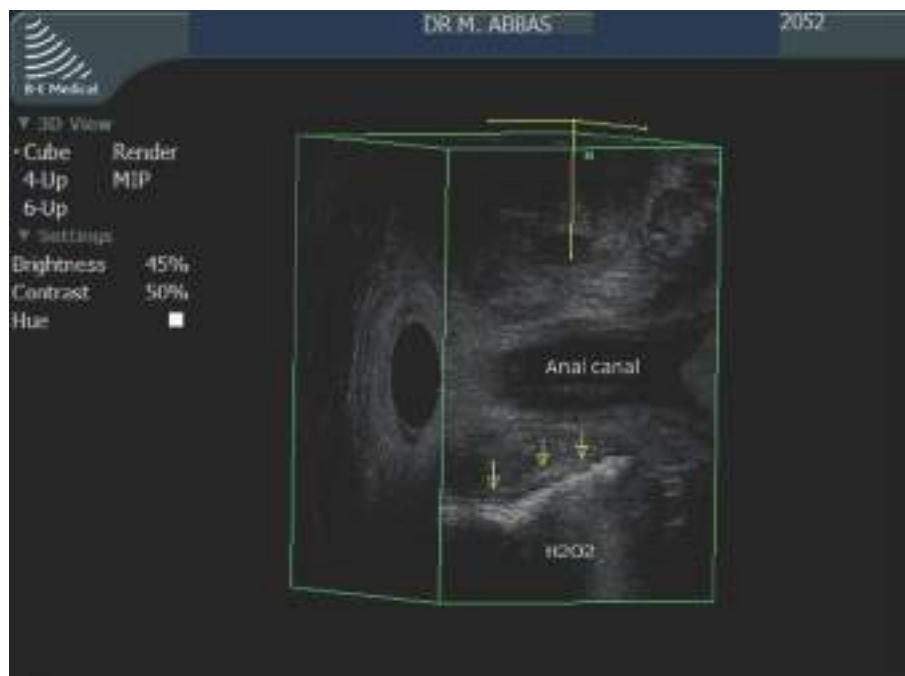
Persistent high transsphincteric anal fistula secondary to cryptoglandular disease [3D endoanal ultrasound].
